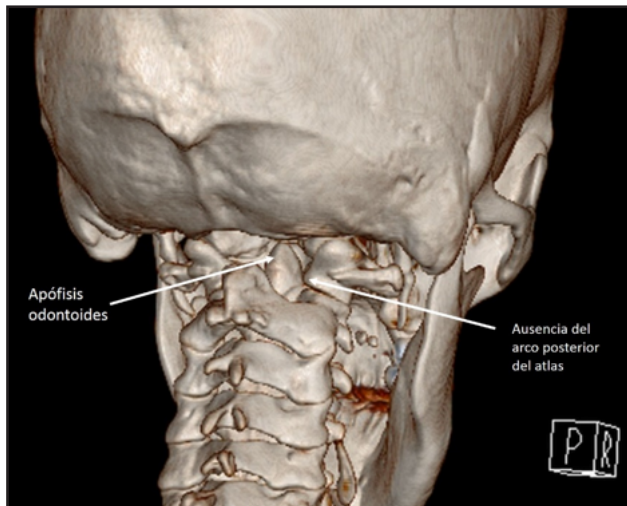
Computed tomography image with 3D reconstruction of the posterior cervical spine, showing total absence of the posterior arch of the atlas, with a direct view of the odontoid process.
